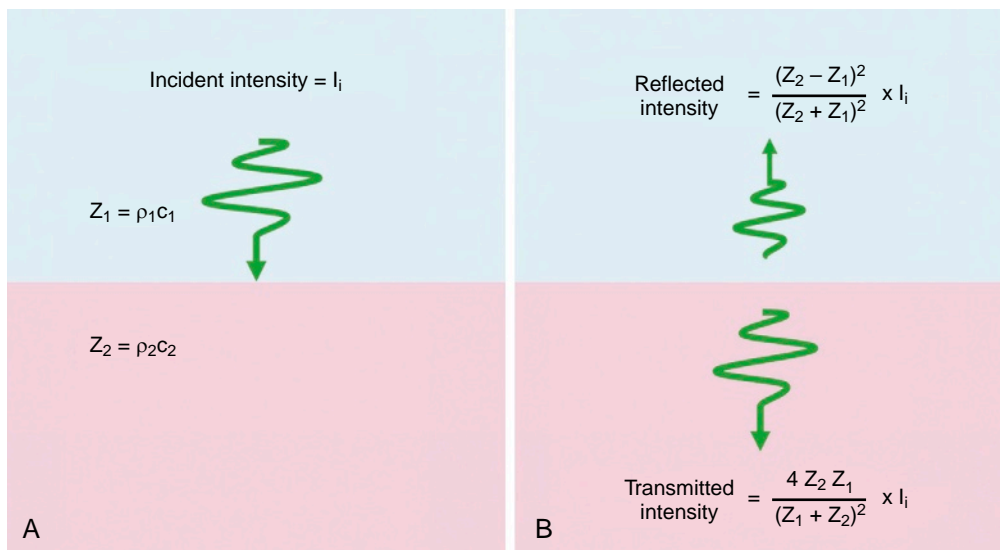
TRANSMISSION AND REFLECTION. Consider a smooth boundary between two types of tissue. The boundary extends out laterally to a distance much greater than the ultrasound wavelength. The acoustic impedance (Z) of each tissue is equal to the density (ρ) times the speed of sound (c). A, A wave with intensity I_i is perpendicularly incident on the boundary. B, The reflected and transmitted intensity is determined by the acoustic impedance values of the two tissues. The greater the difference in impedance, the stronger the reflected intensity.
